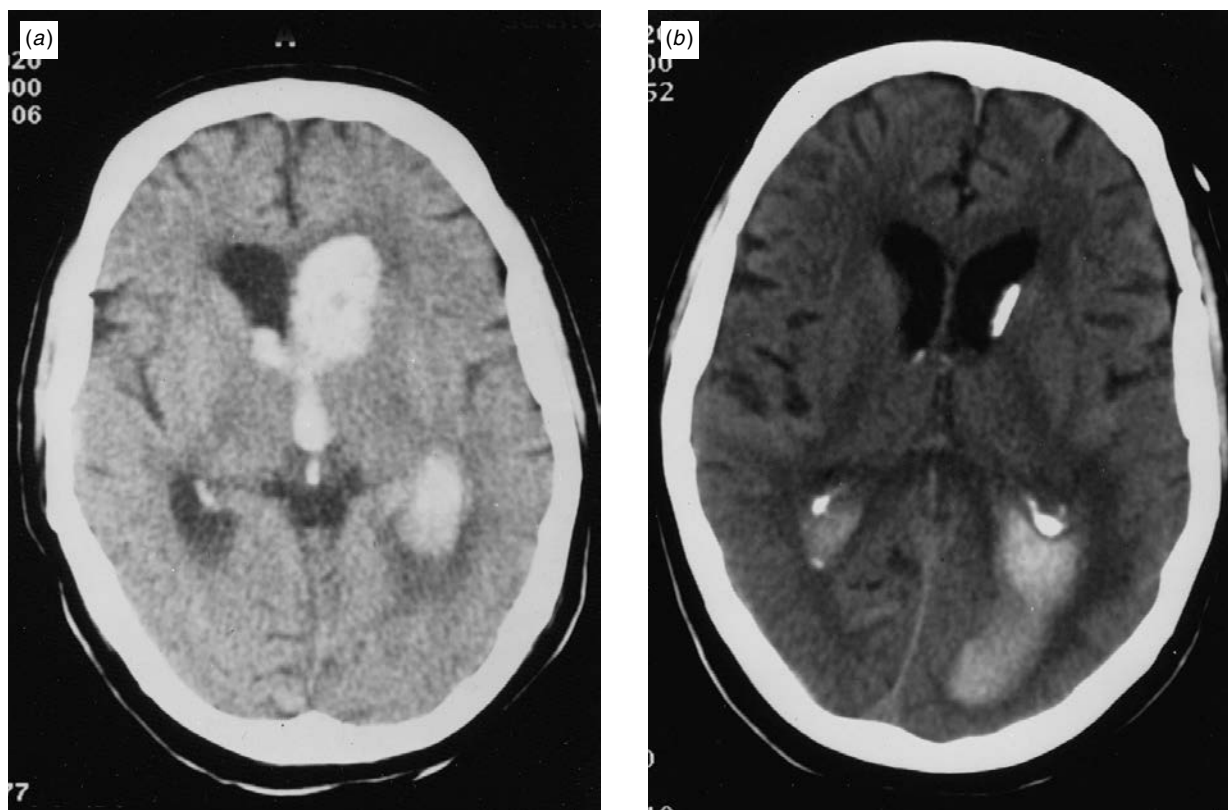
(a), (b). Head CT scan of an 81-year-old man with intraventricular hemorrhage. The blood clot has casted the left frontal, left temporal and third ventricles. Mild spillage of blood is seen in the right frontal horn. Blood in the ventricles led to the formation of an obstructive-type hydrocephalus. The insertion of a left intraventricular catheter (b) facilitated drainage of CSF and blood and the relief of the obstructive hydrocephalus.
